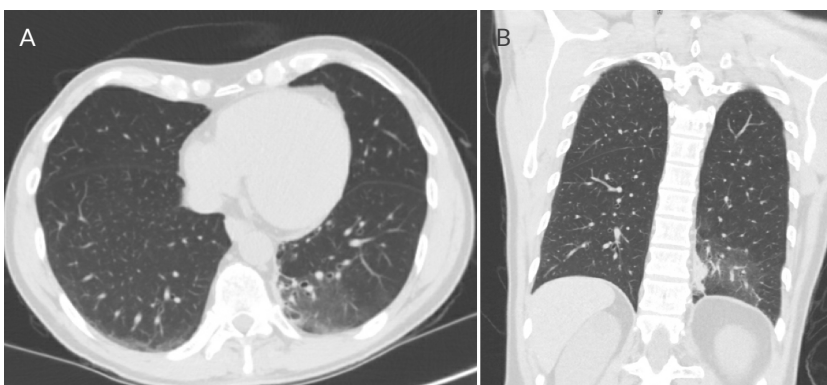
Repeat CT scan of the chest obtained four weeks after discharge showing improvement in left lower lobe lung consolidation in A) cross-sectional and B) coronal view.
